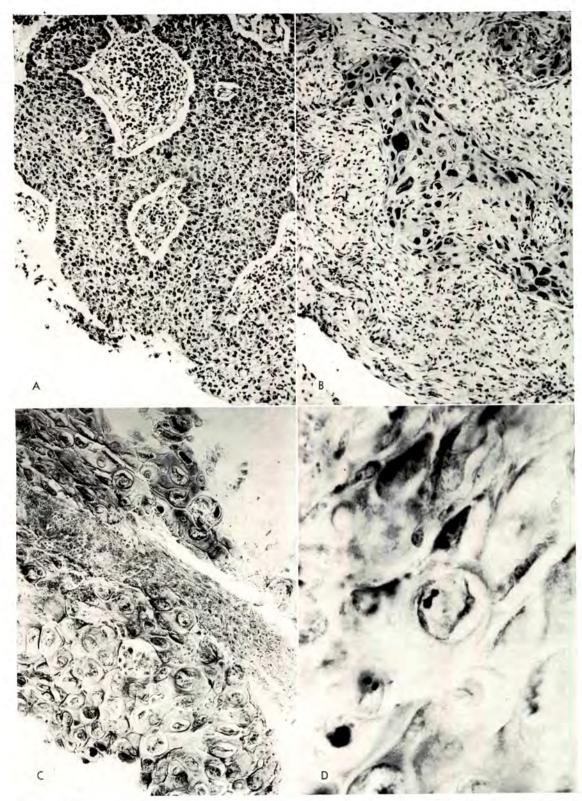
Tissue sections. RST good. Cancer of the cervix, Stage 1c. Treatment: Transvaginal cone therapy, radium, external roentgen irradiation. The patient is alive and well without disease for four years. (A) H & E, control, ×207. (B) H & E, ×207 (7 days after 3,000 r by transvaginal cone). (C) MGP, ×207 (7 days after 3,000 r by transvaginal cone). (D) MGP, ×828 (7 days after 3,000 r by transvaginal cone).
